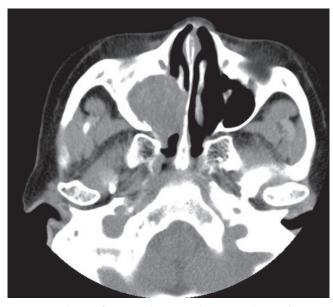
Axial view of computed tomography (case 2) showing bone erosion of the posterolateral and medial wall of right maxillary sinus.
